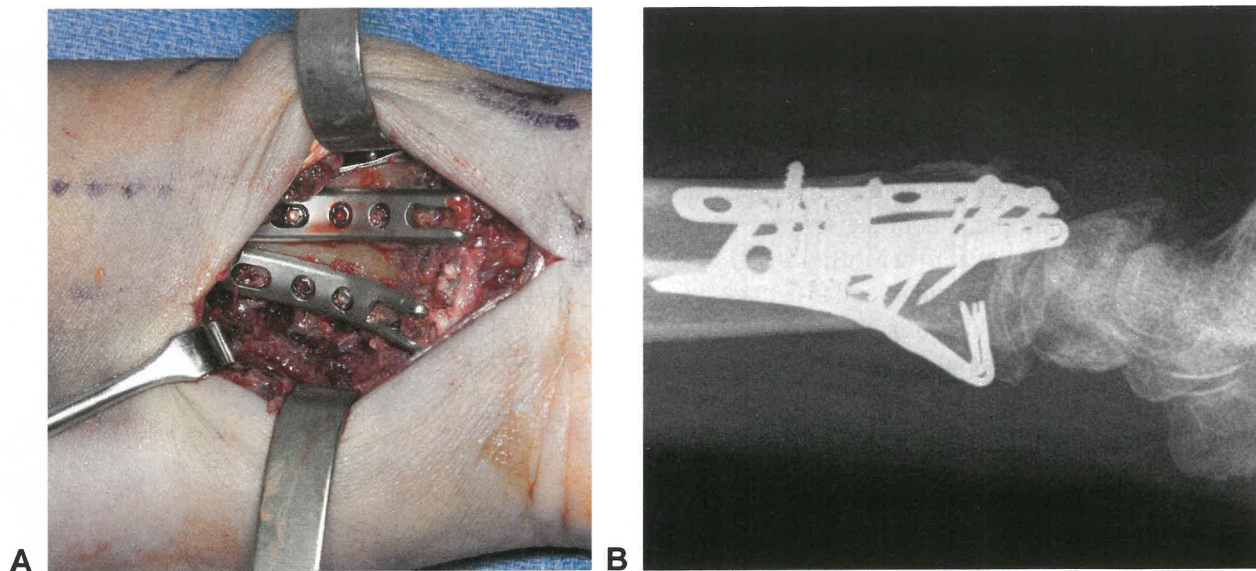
Patient with second-generation plates that are well-seated with tines flush with the volar cortex noted in this A intraoperative photograph and B postoperative radiograph.
